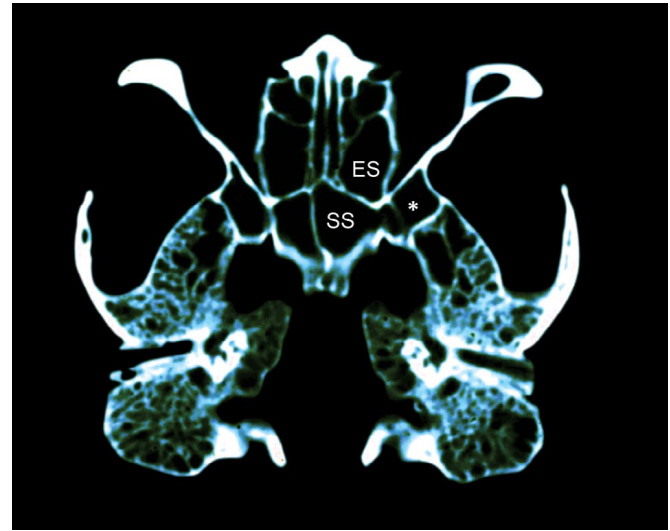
An axial computed tomography scan of a gorilla cranium. Note the distinct, two-celled ethmoid sinus (ES) and the extensive sphenoid sinus (SS), which may be seen invading the greater wing of the sphenoid (asterisk).
